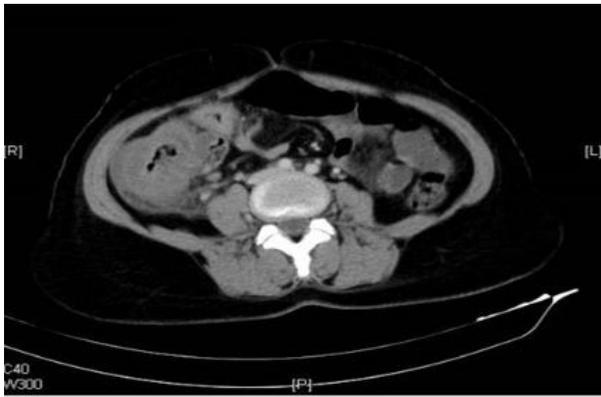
CT image of wall thickening in the cecum
